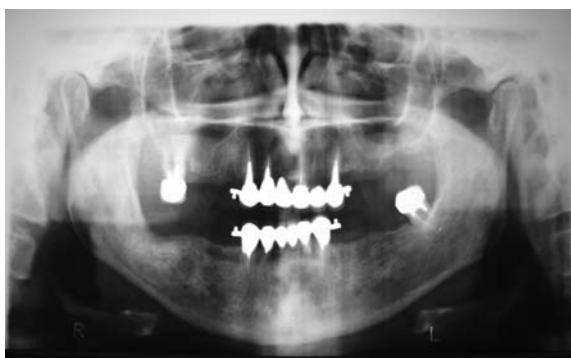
The orthopantomogram of patient S.H., 69 years
